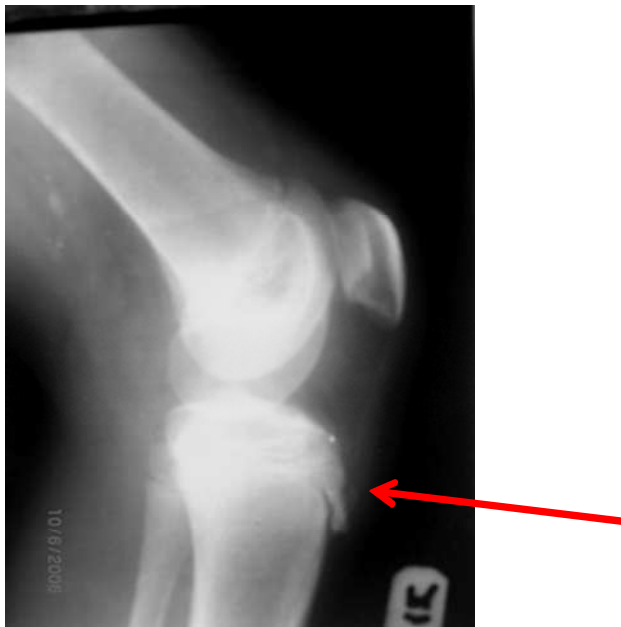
Plain radiograph of the right knee joint showing soft tissue swelling anterior to the tibial tubercle (red arrow)
